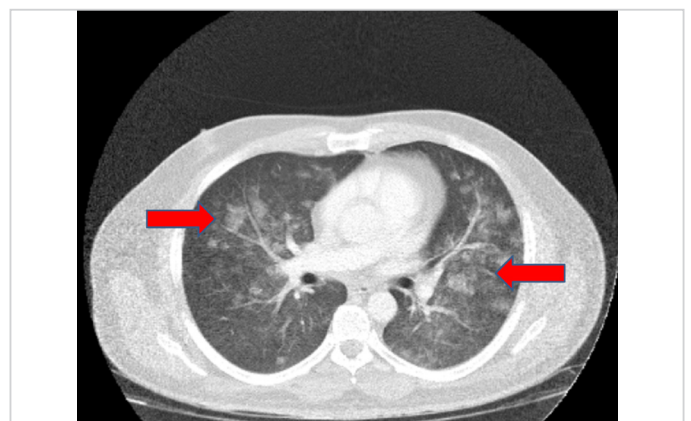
NPPE thoracic CT axial image (arrows)
